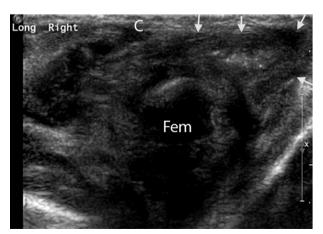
Ultrasound scan at 3 weeks of age. Right parasagittal image from a posterior approach (patient prone) showing herniated bowel extending into the ischioanal fossa well below the pelvic floor (short arrows). C = coccyx, Fem = medial aspect of right femoral head.
